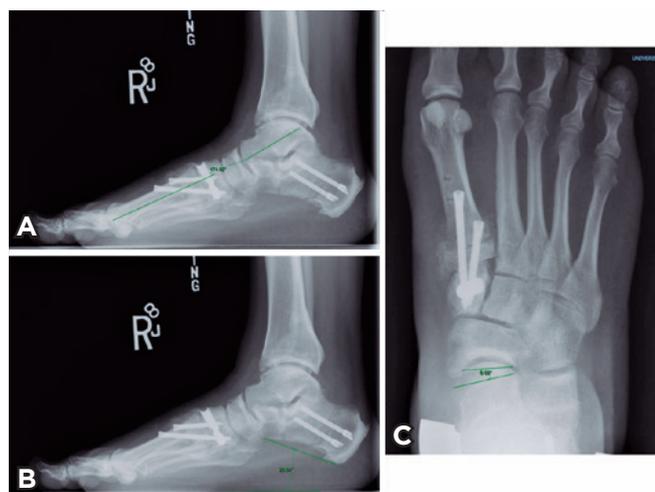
Postoperative radiographs obtained during the third-month follow-up visit, showing the Meary's angle (A), the talonavicular coverage angle (B) and the calcaneal pitch angle (C).
